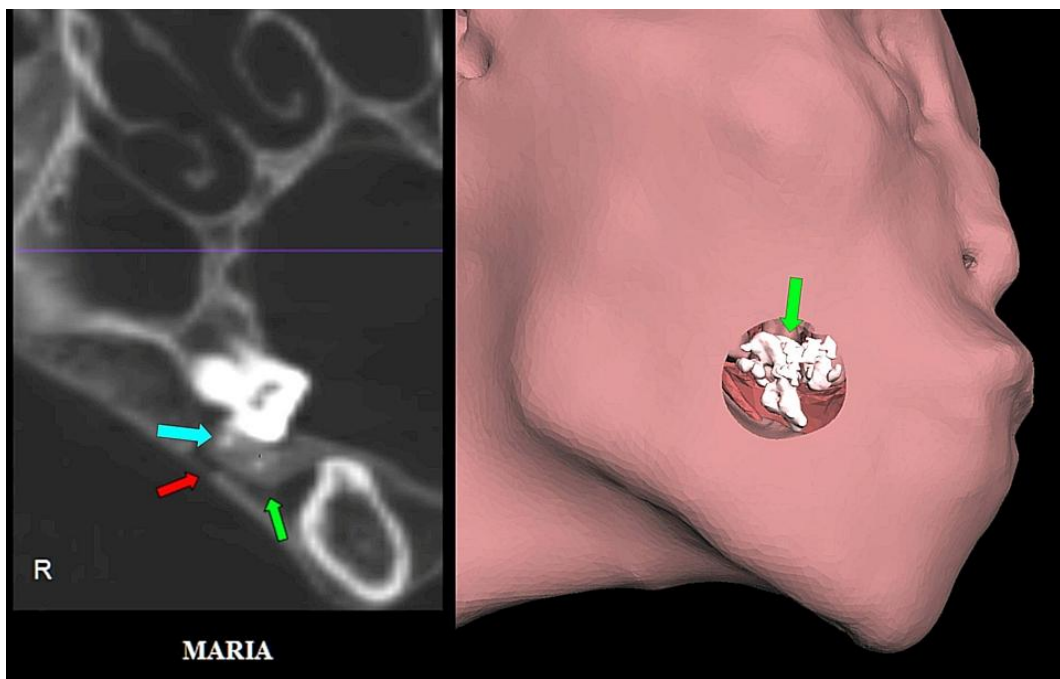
2D coronal CT scan (*left*) and 3D CT of right side of face (*right*) with digital window created exposing irregular mineral content (*green arrow*) containing multi-focal tiny calcifications (*blue arrow*) deep within the right buccal wall adjacent to the R upper first and second molar teeth. A tiny skin puncture hole (*red arrow*) could be identified overlying the lesion on 2D scan.
